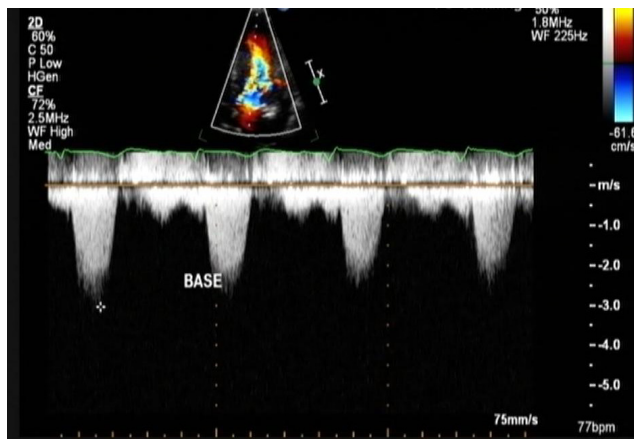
Color flow Doppler study of the patient showing a peak instantaneous gradient of 37 mmHg at post-implantation of dual chamber pacemaker. (This was previously described as 194 mmHg before implantation of pacemaker)
